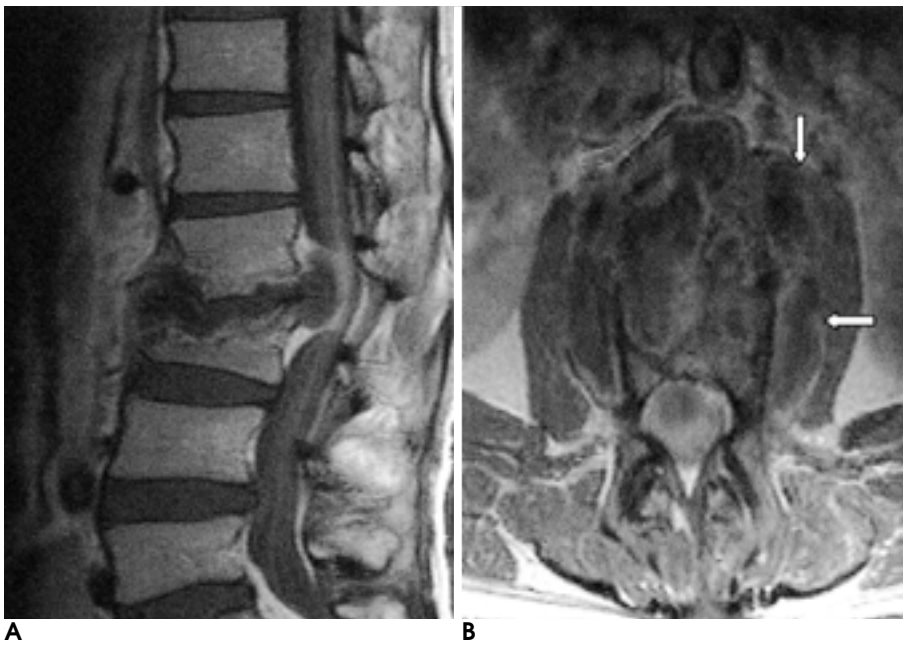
A 48-year-old woman with lumbar tuberculous abscess. Contrast enhanced sagittal (A) and axial (B) T1-weighted images show a large epidural and paraspinal abscess with heterogenous enhancement. Psoas abscess is present(arrows).
